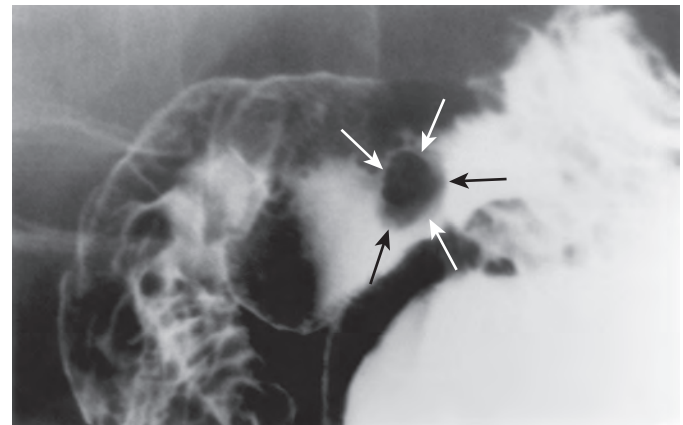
Early duodenal cancer. Double-contrast spot image of the duodenum shows a sessile, slightly lobulated, 1.3-cm polypoid lesion (arrows) in the duodenal bulb. This was an early cancer that was confined to the mucosa. (From Bradford D, Levine MS, Hoang D, et al: Early duodenal cancer: Detection on double-contrast upper gastrointestinal radiography. *AJR* 174:1564-1566, 2000.)
